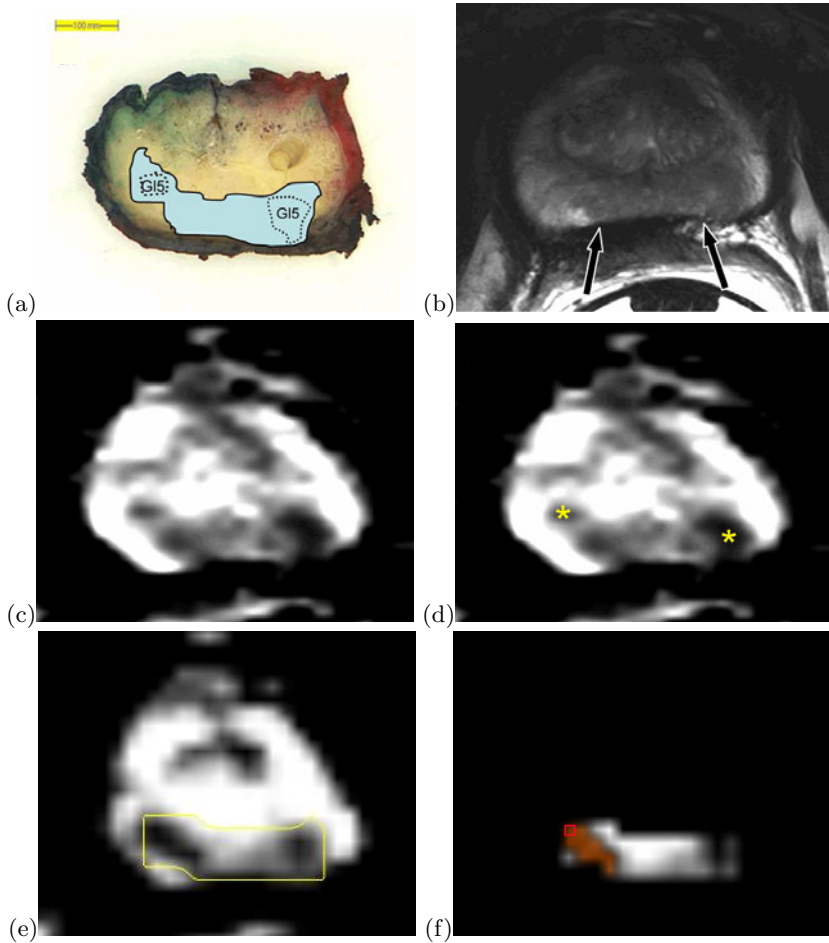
Patient with a peripheral zone tumor revealing Gleason 3 + 4 + 5 on final pathology. (a) Prostatectomy step-section with the tumor delineated in light blue. Regions with focal Gleason grade 5 on pathology are delineated with a dotted line. (b) Anatomical T2 weighted MR image. A large tumor region corresponding to the step-section is shown in the peripheral zone as indicated by the arrows. (c) On the ADC map, water restriction is clearly visible for the same lesion. (d) The Gleason 5 components are visible as dark regions (yellow asterisks). (e) Regions of interest annotated on the smoothed ADC map in correspondence with prostatectomy step-section (yellow delineation). (f) The segmentation of the hotspot finding based on ADC values (orange region). The red square indicates the seed point for the region growing.
